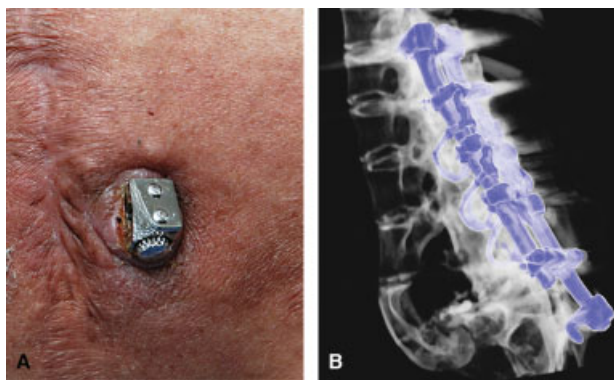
(A) Caudal end of the right spondylodesis pole perforating the sacral skin 14 years after initial surgery. (B) Three-dimensional reconstructed computed tomography scan reveals posterior fusion from T12 to S1 (Harrington) with secondary shortened pole below L5 on the left and the evulsion of the S1 screw on the right side.
